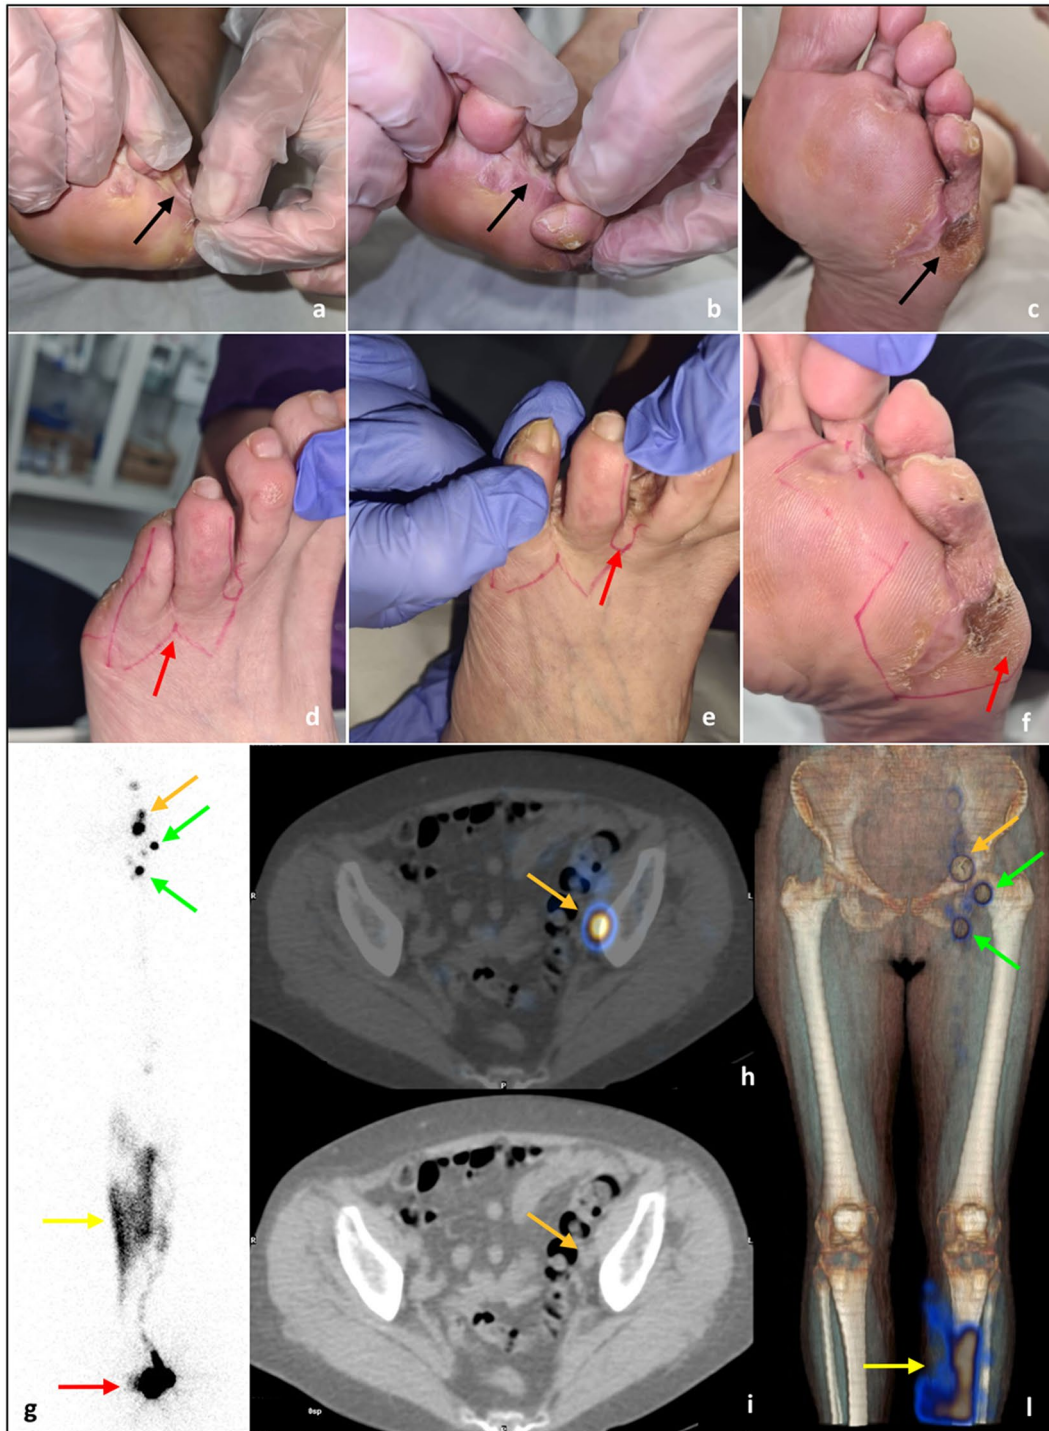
Lymphoscintigraphy of an 83-year-old female with recurrent acral lentiginous melanoma on the third and fourth interdigital space (a and b) and lateral surface of the left foot (c), behind the skin graft (clinical case #5). d–f Intradermal injection sites of ^{99m}Tc -nanocolloids: 2 on the dorsum and one on the lateral surface of the left foot (red arrows). g Planar lymphoscintigraphy of the lower limbs (anterior view), acquired with dual-head gamma-camera (Optima NM/CT 640, GE, Milwaukee, USA). The image recorded three areas of radiopharmaceutical uptake in the left groin. The image also showed a
